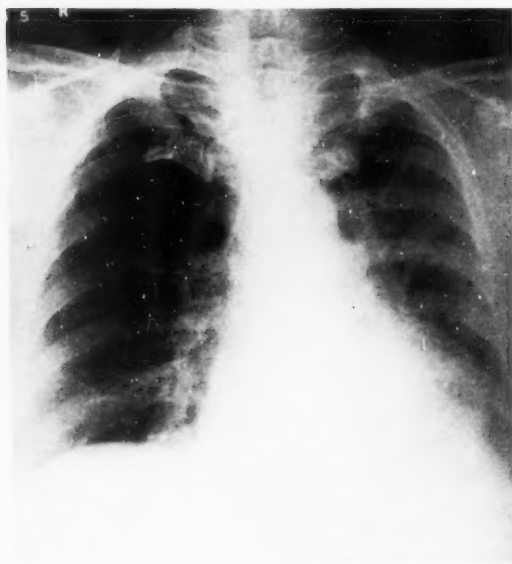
(a) — Moderate to Marked Reaction — Mrs. J. B., 63 yrs; quadrate radiation to left chest to a dose of 7700 r in 80 days. X-ray changes first appeared 4 weeks after treatment and progressed to this extent by 8 weeks. At no time did the patient experience signs or symptoms referable to the lungs.
